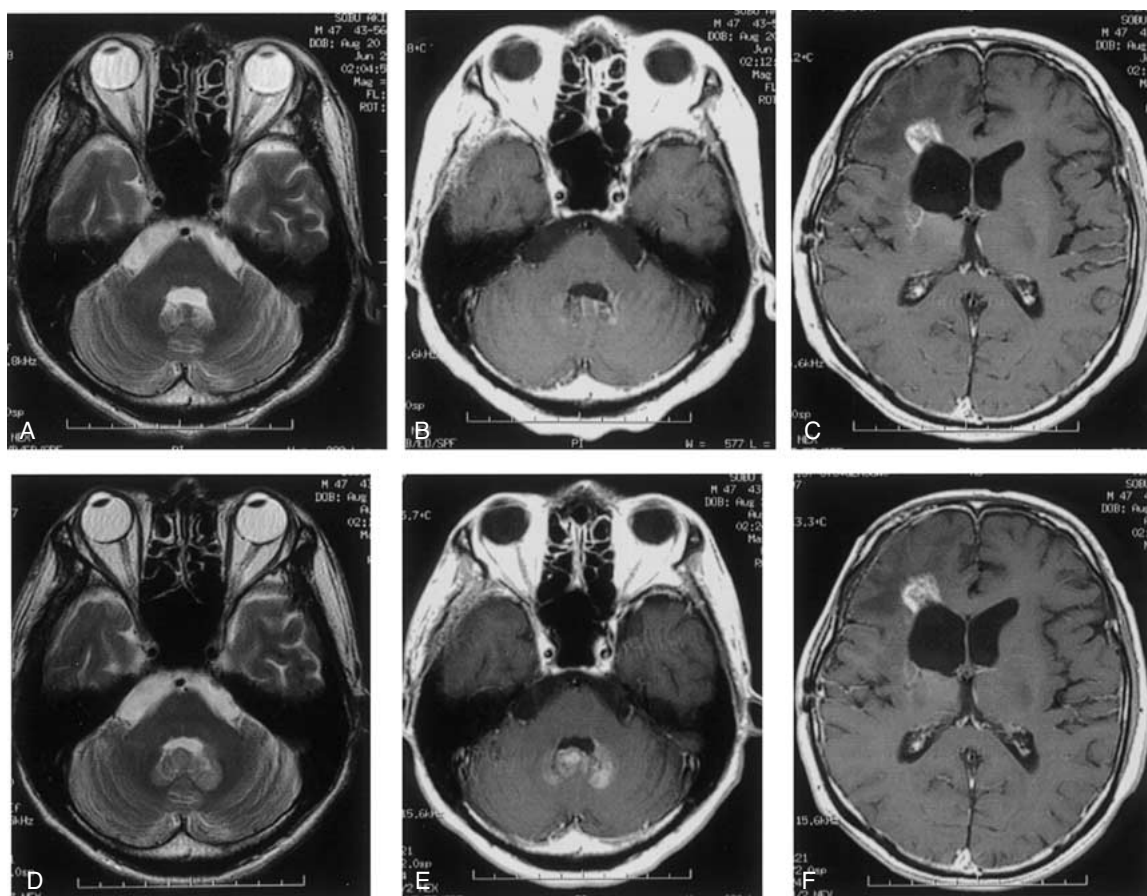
Case 5. T2-weighted (A, D) and T1-weighted MR images with Gd-DTPA (B, C, E, F). The CSF seeding was not evident around the fourth ventricle 1 month after presentation with intractable vomiting (A–C), but appeared 2 months later (D–F).
